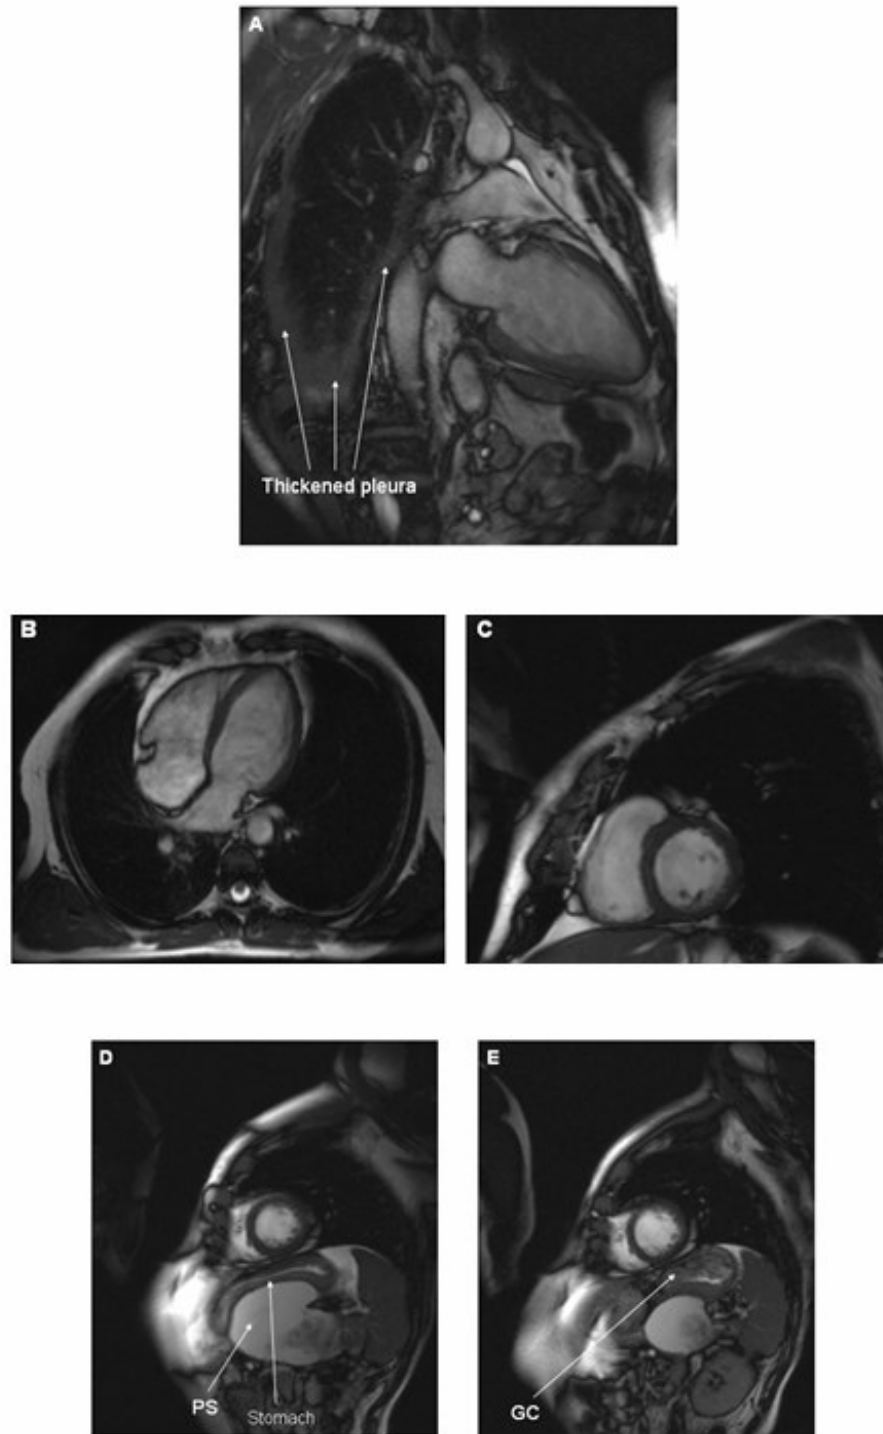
Extracardiac abnormalities. (A) Oblique vertical long-axis CMR view of a 69-year-old patient admitted with an inferior STEMI. Admission chest X-ray suggested consolidation at the right lung base, but CMR suggests diffuse pleural thickening consistent with mesothelioma (arrows). (B) Horizontal and (C) short-axis CMR views of a 48-year-old non-smoker admitted with an anterior NSTEMI. Bullous hyper-expansion of both lung fields apparent (more marked on the left), with medial displacement of the mediastinum and its contents. (D) CMR short-axis view of 50-year-old patient with chronic pancreatitis, admitted with an inferior STEMI. A large pancreatic pseudocyst (PS) is present, visibly compressing the stomach. (E) After 3 months of conservative therapy, there is a marked reduction in the size of the PS, with less compression of the stomach and visible gastric contents (GC).
